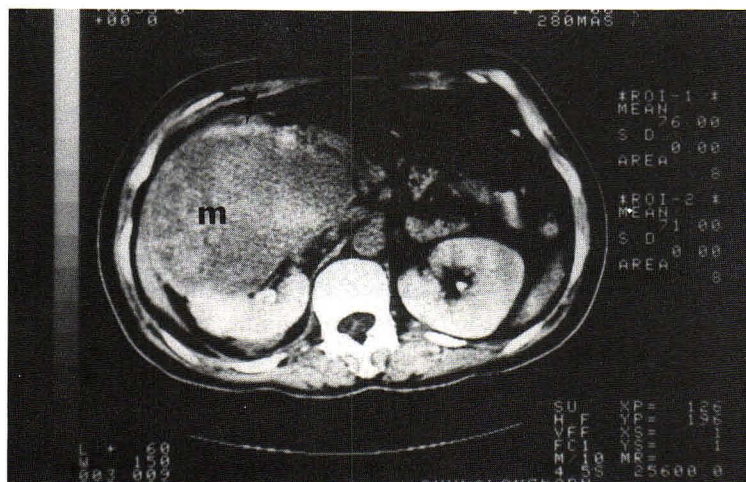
An enhanced axial CT scan shows an inhomogeneously enhanced mass with irregular rim calcification (arrow head) in the right kidney (m).
